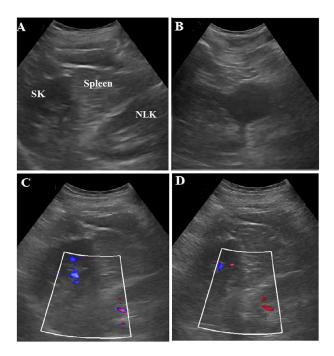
Gray-scale image if supernumerary and native left kidney with well-defined central hyperchoic renal sinus fat and hypoechoic peripheral parenchyma (A). Gray scale of solitary renal cyst of native left kidney (B) Doppler ultrasound images demonstrating separate vascular supply within both supernumerary left kidney and native left kidney (C, D).
